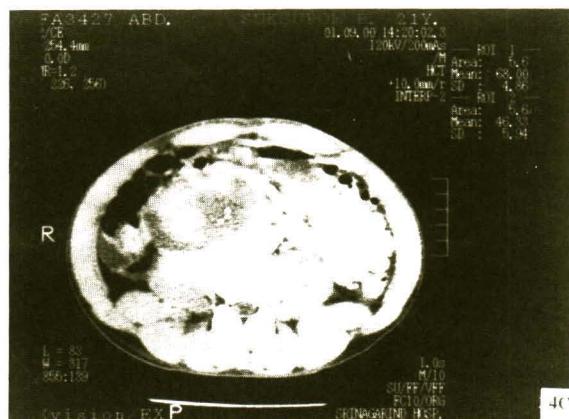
Enhanced CT scan demonstrates minimal enhanced rim on portovenous phase. The duodenal hematoma displaced duodenal lumen and inferior vena cava.
